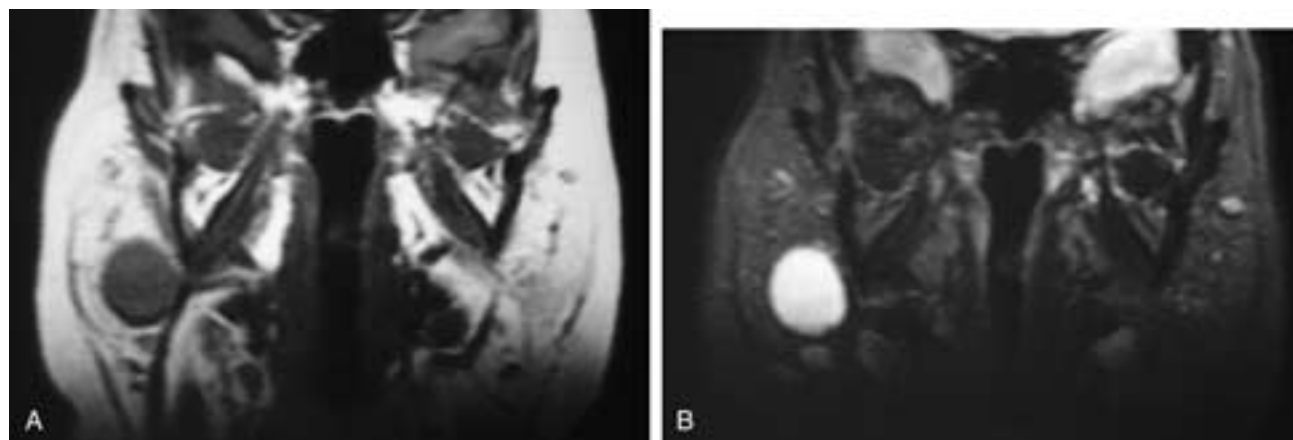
Coronal T1-weighted (A) and T2-weighted (B) MR images show a well-delineated right parotid mass that has a low signal intensity in A and a high signal intensity in B. These “water” signal intensities reflect the high serous and mucinous differentiation of this tumor. This is a nonspecific appearance. This patient had a pleomorphic adenoma.
